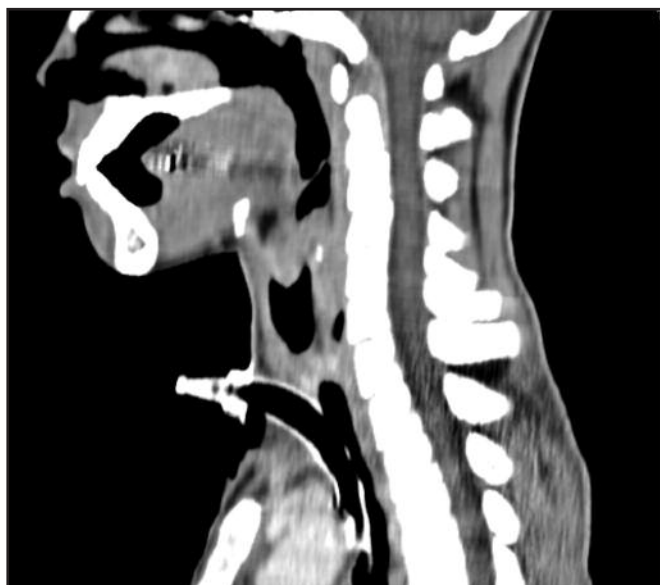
Computed tomography scan, sagittal section. An interrupted radiolucency of the trachea superior to the level of the tracheostomy.
